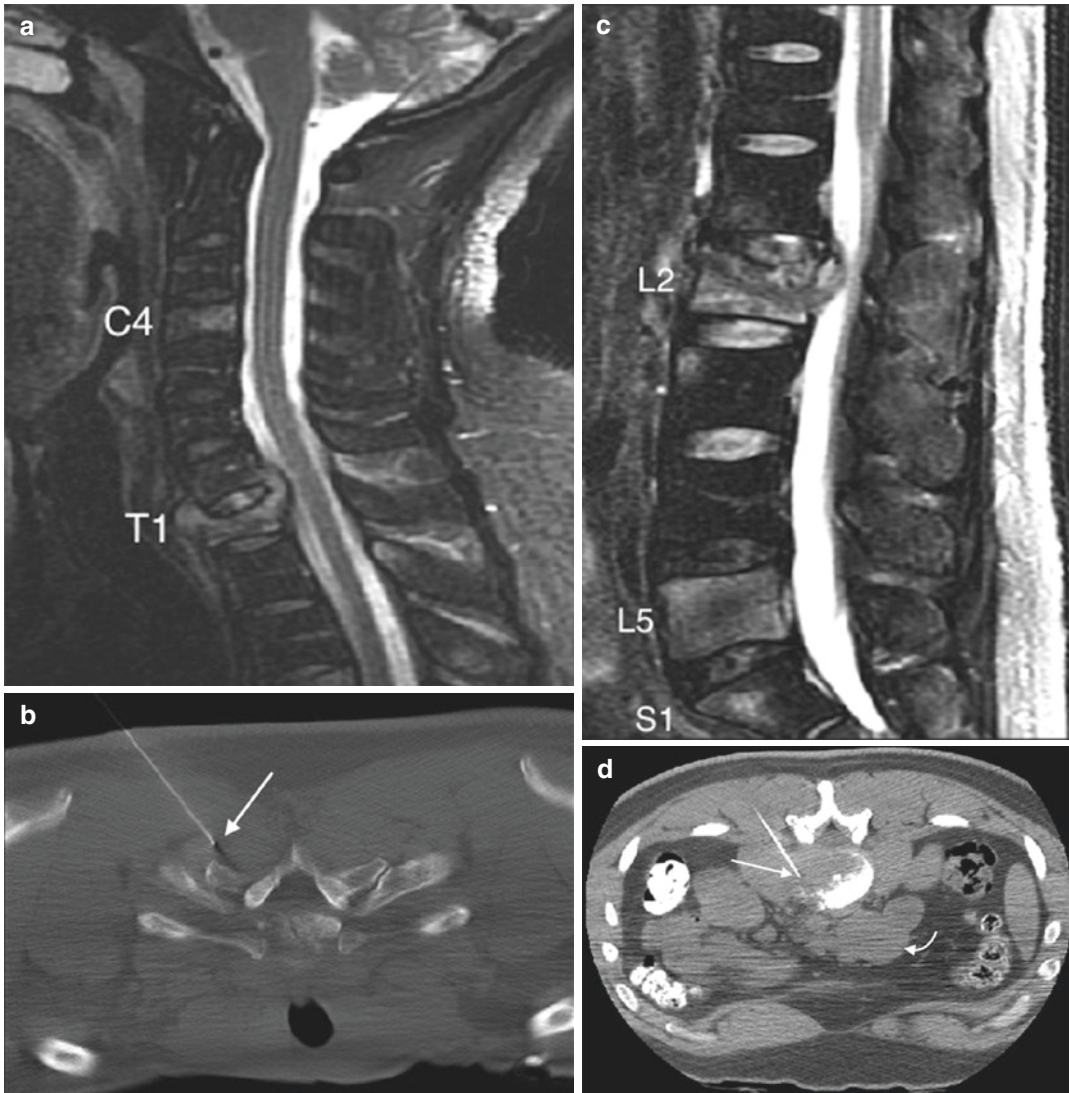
30 year-old male with multiple spine lesions. Fat-suppressed T2 sagittal MR image of cervical spine (a) shows a C4 and T1 vertebral body lesions. The operator attempted to biopsy T1 via a posterior approach (arrow) without success (b). STIR sagittal MRI image of lumbar
